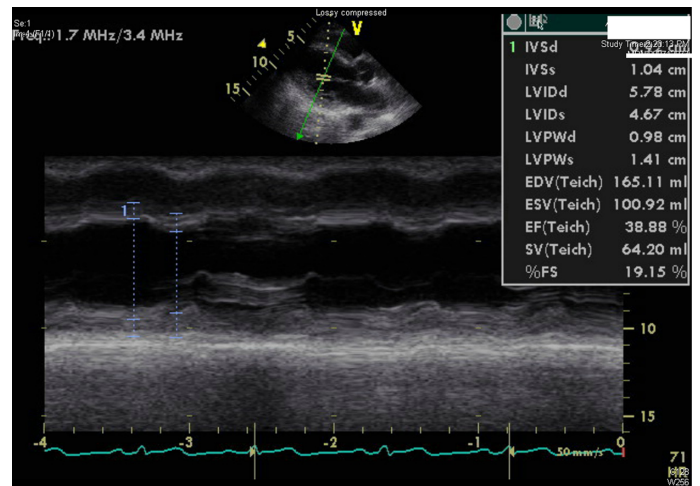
M-mode Echocardiogram through mid Left Ventricle (LV) showing hypokinesia of antero-septal and infero-lateral walls and depressed LV function.
